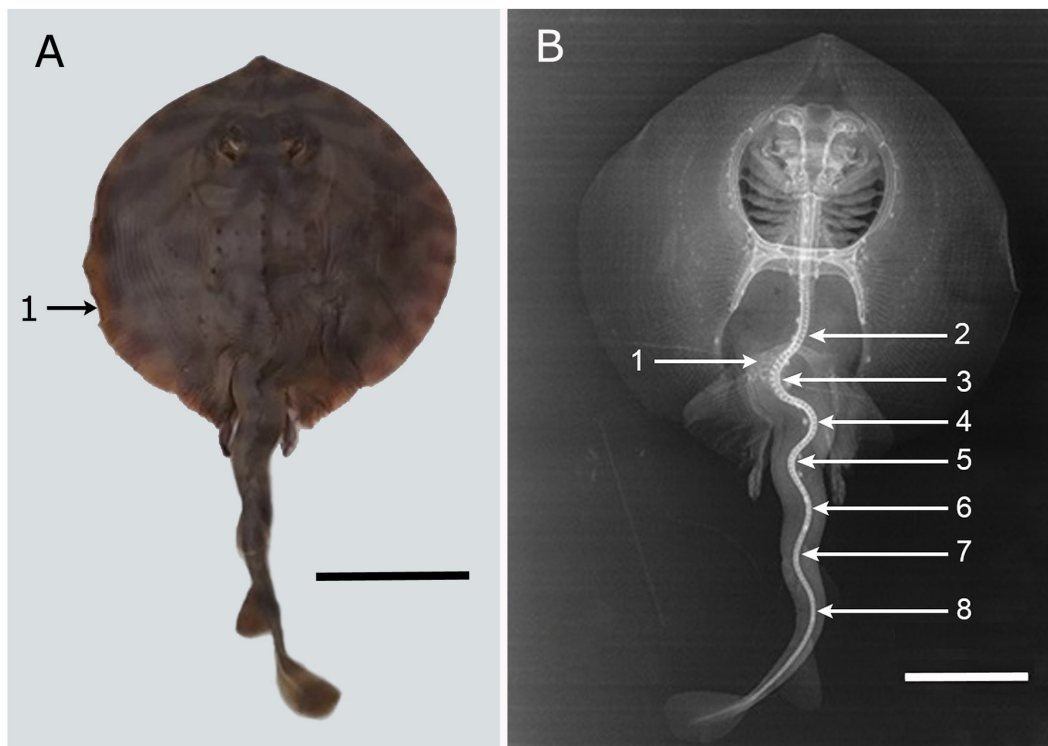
Zanobatus schoenleinii* (Ref. ISPAB-Zan-sch-06). A. Dorsal surface. 1. indicating serrations of the left margin of the pectoral fin, scale bar= 80 mm. B. X-ray radiography indicating 1. Pelvic girdle. 2. Scoliosis of truncal vertebrae. 3-8. Tail curvatures, scale bar= 60 mm / *Zanobatus schoenleinii* (Ref. ISPAB-Zan-sch-06). A. Superficie dorsal. 1. indica estrías en el margen izquierdo de la aleta pectoral, barra de escala= 80 mm. B. Radiografía indicando 1. Cintura pélvica. 2. Escoliosis de las vértebras del tronco. 3-8. Curvaturas caudales, barra de escala= 60 mm
